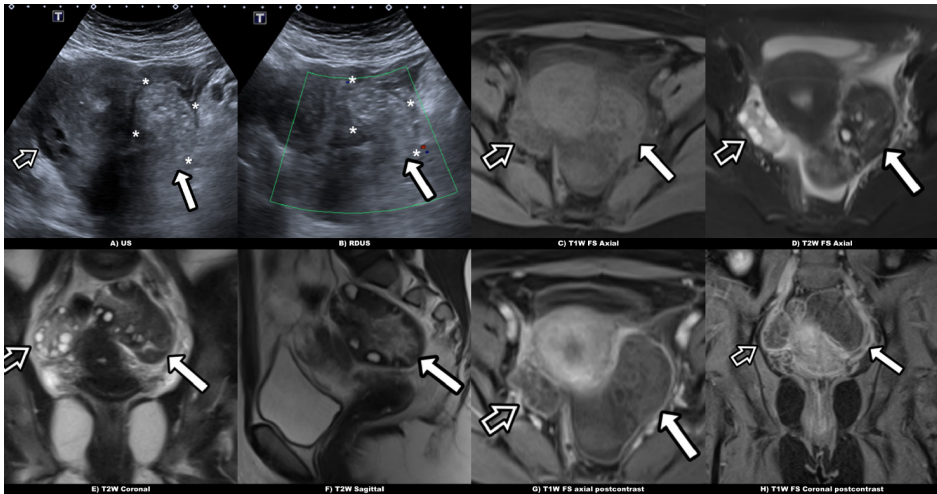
US and MRI images of adnexal torsion.
